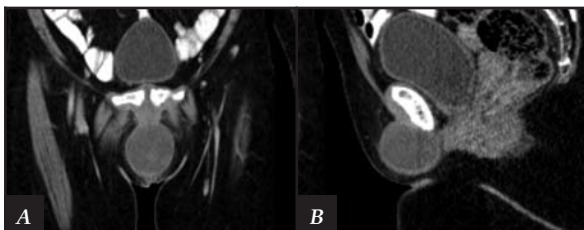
Coronal (A) and sagittal (B) post-contrast computed tomography images demonstrate the subpubic position of the cyst with its close relation to the pubic symphysis.
